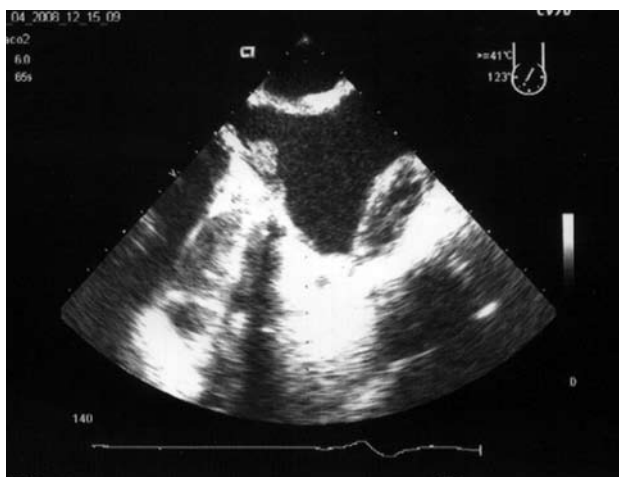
Transoesophageal echocardiogram showing a thrombus on the lateral hemidisc of the tricuspid valve prosthesis (shot from four cameras modified at 120° and with a maximum rotation towards the right).
